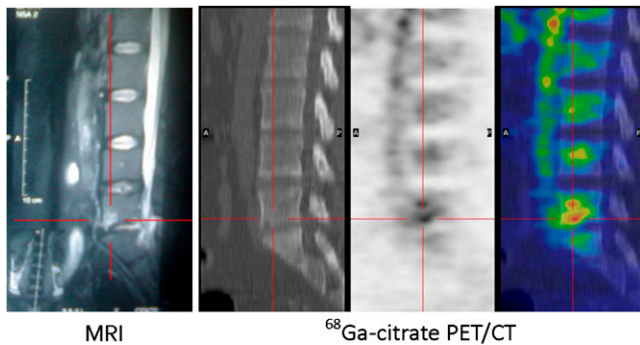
Comparison of spine MRI and ^{68}Ga -citrate PET/CT in patient with diskitis. MRI shows area of abnormal signal in L5–S1 that is not unequivocally consistent with infective diskitis (patient 24). ^{68}Ga -citrate PET/CT shows focal area of increased tracer uptake consistent with inflammation (SUVmax, 5.3).
